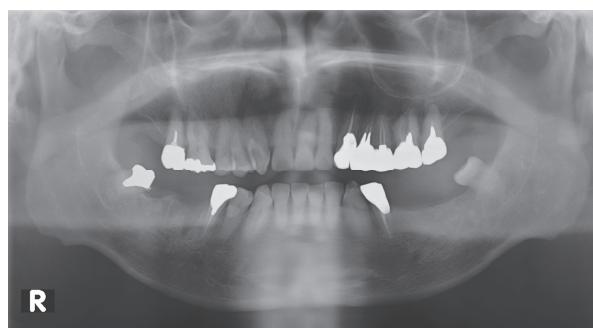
Panoramic Radiography photograph at the first visit
